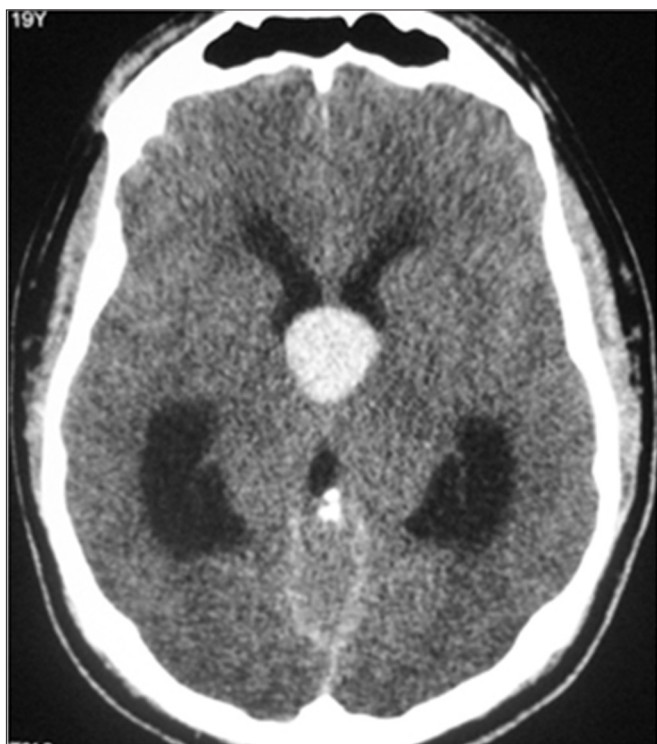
Computed Tomography Imaging without contrast. 19-year-old male with a hyperdense nodule of 2.5 cm in the rostral aspect of the third ventricle.
